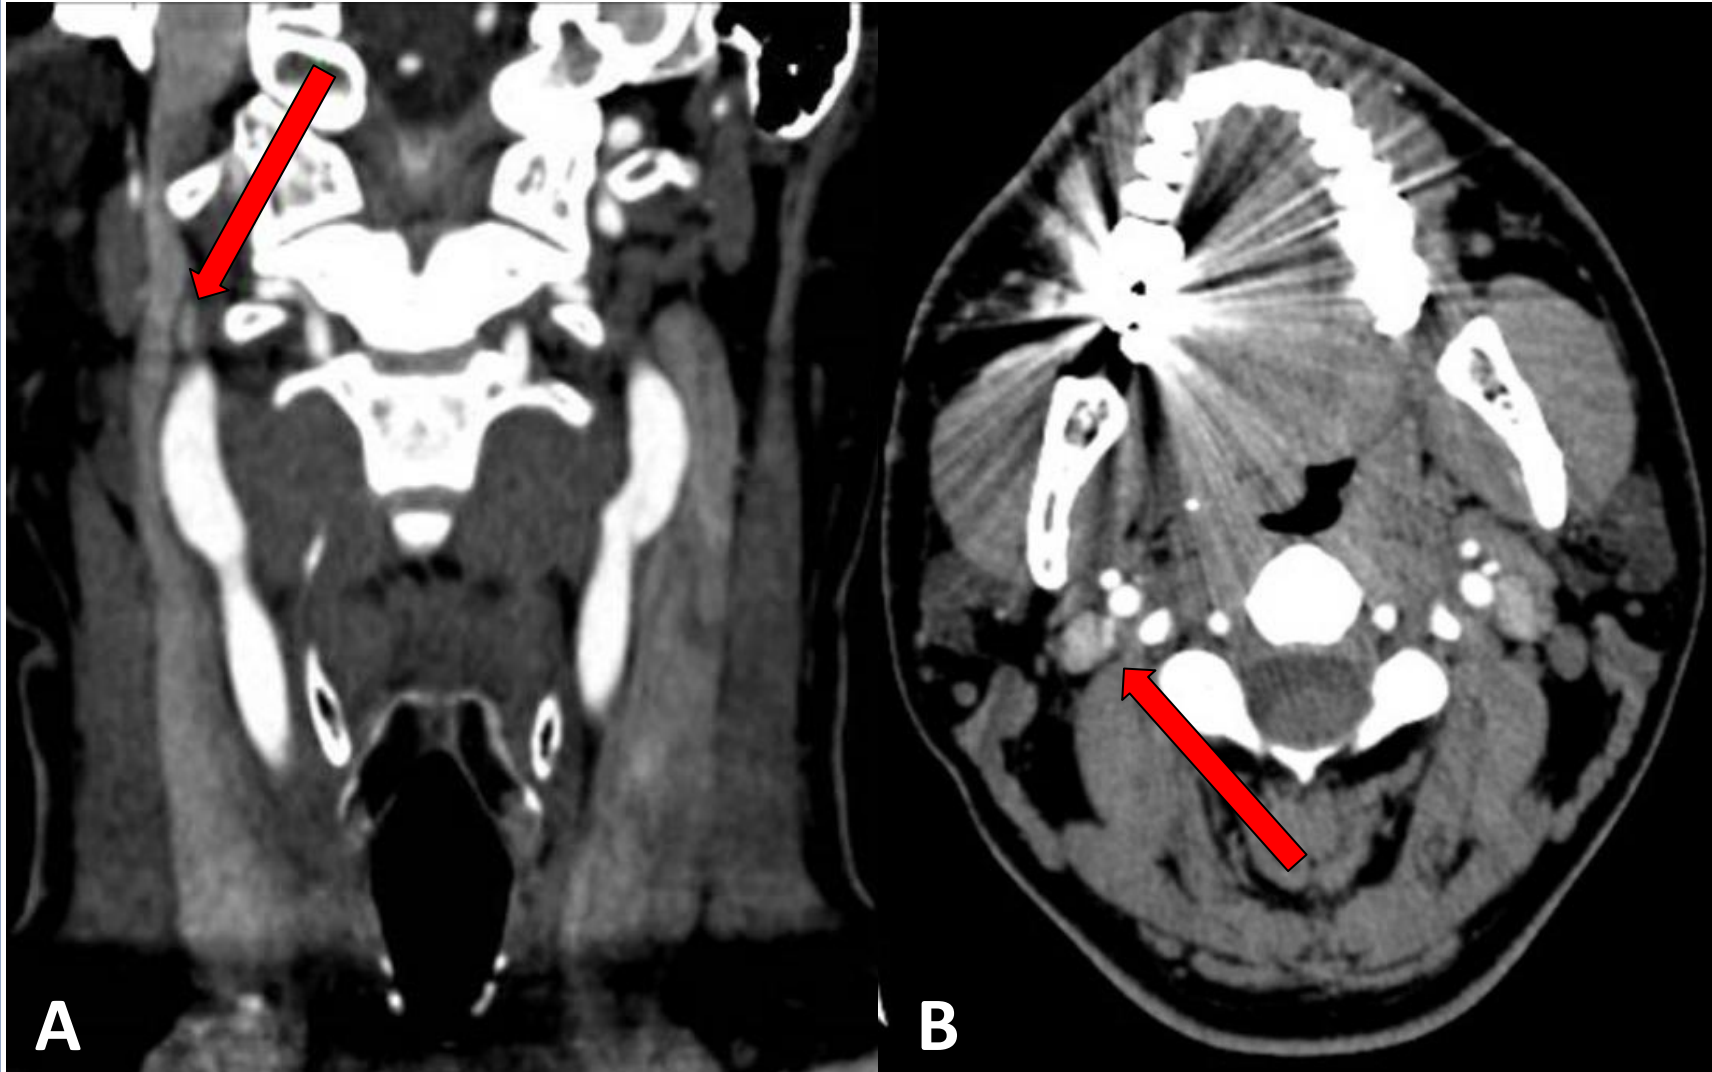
Patient A second 4D CT scan findings. A. Coronal plane imaging with red arrow indicating potential parathyroid adenoma at right skull base. B. Axial plane imaging with red arrow indicating potential parathyroid adenoma at right skull base.
